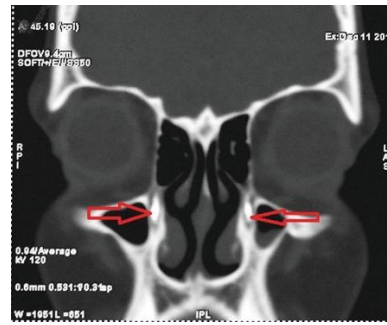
CT Scan Image of the Lacrimal System
